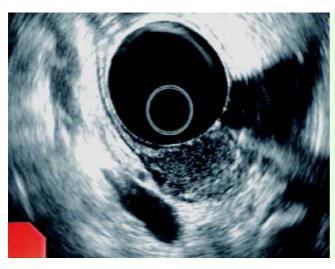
A large submucosal mass was seen at the body of the stomach by radial endoscopic ultrasound (Olympus, Tokyo, Japan). The lesion was heterogeneous with a small anechoic area.
